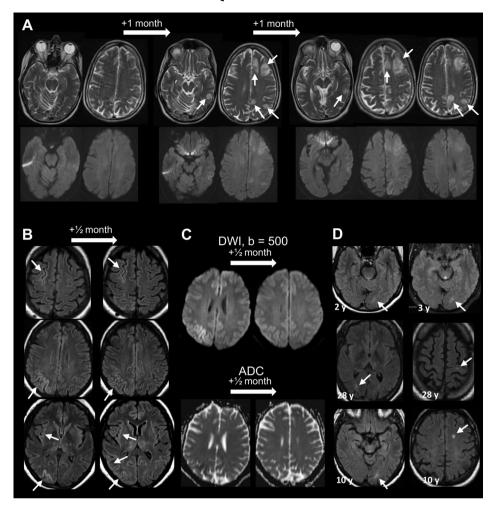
Cerebral MRI findings in POLG-related ataxia. (A) Stroke-like cortical and adjacent subcortical lesions (P06); on the left 2 days after an epileptic seizure, in the middle after 1 month, and on the right after another month. (B, C) FLAIR lesions (P18, immediately after a series of 4 epileptic seizures and 16 days later). (B) Arrows, decreasing signal in the parietal and occipital lobes, increasing signal in the temporal lobe. (D) White-matter lesions on FLAIR images. Upper row: P23, slightly increasing within 1 year (arrows); middle row: blurry WM lesions in P19 (arrows) and additional hyperintense thalamus lesion; lower row: blurry lesions in P12 (arrows). Disease duration is given at the bottom left of each image.
